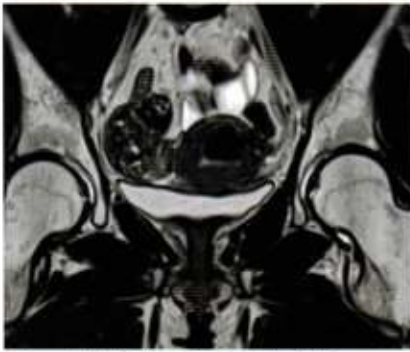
MRI at 4 months postembolization.
